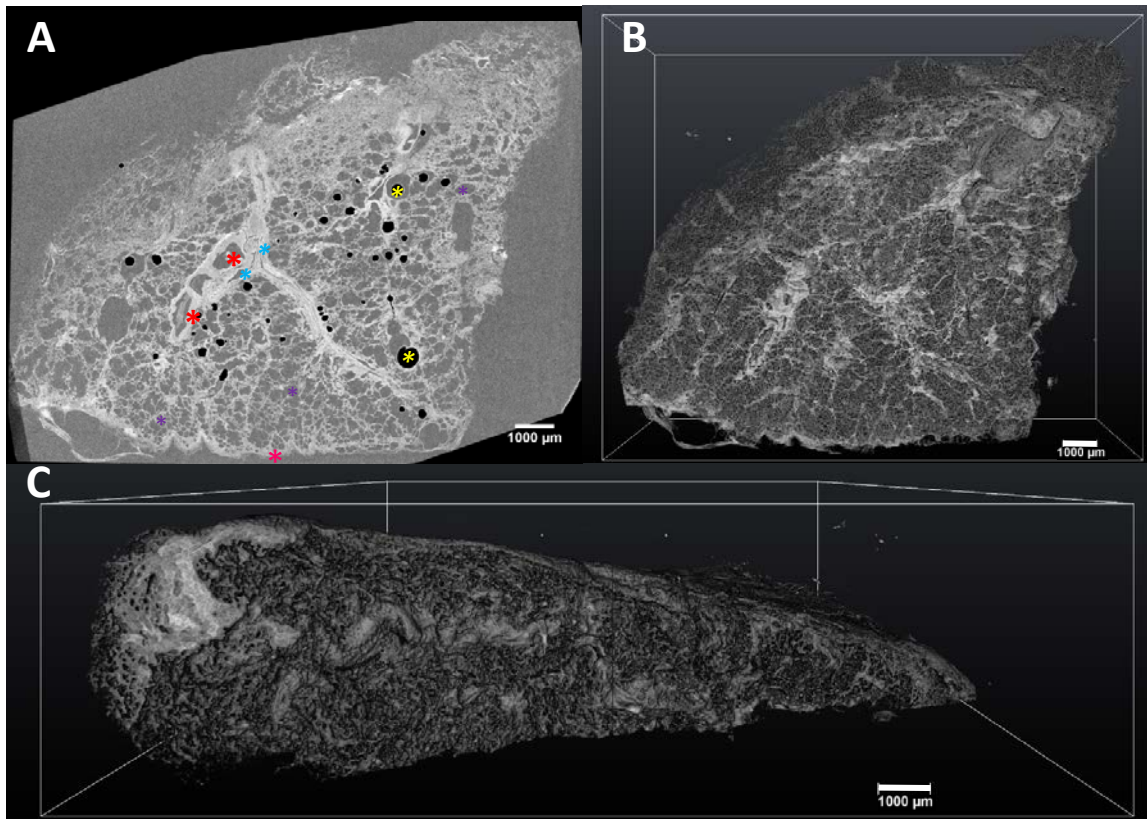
Exemplar reconstructed  $\mu$ CT data in 2D and 3D of FFPE human lung tissue sample. A:
